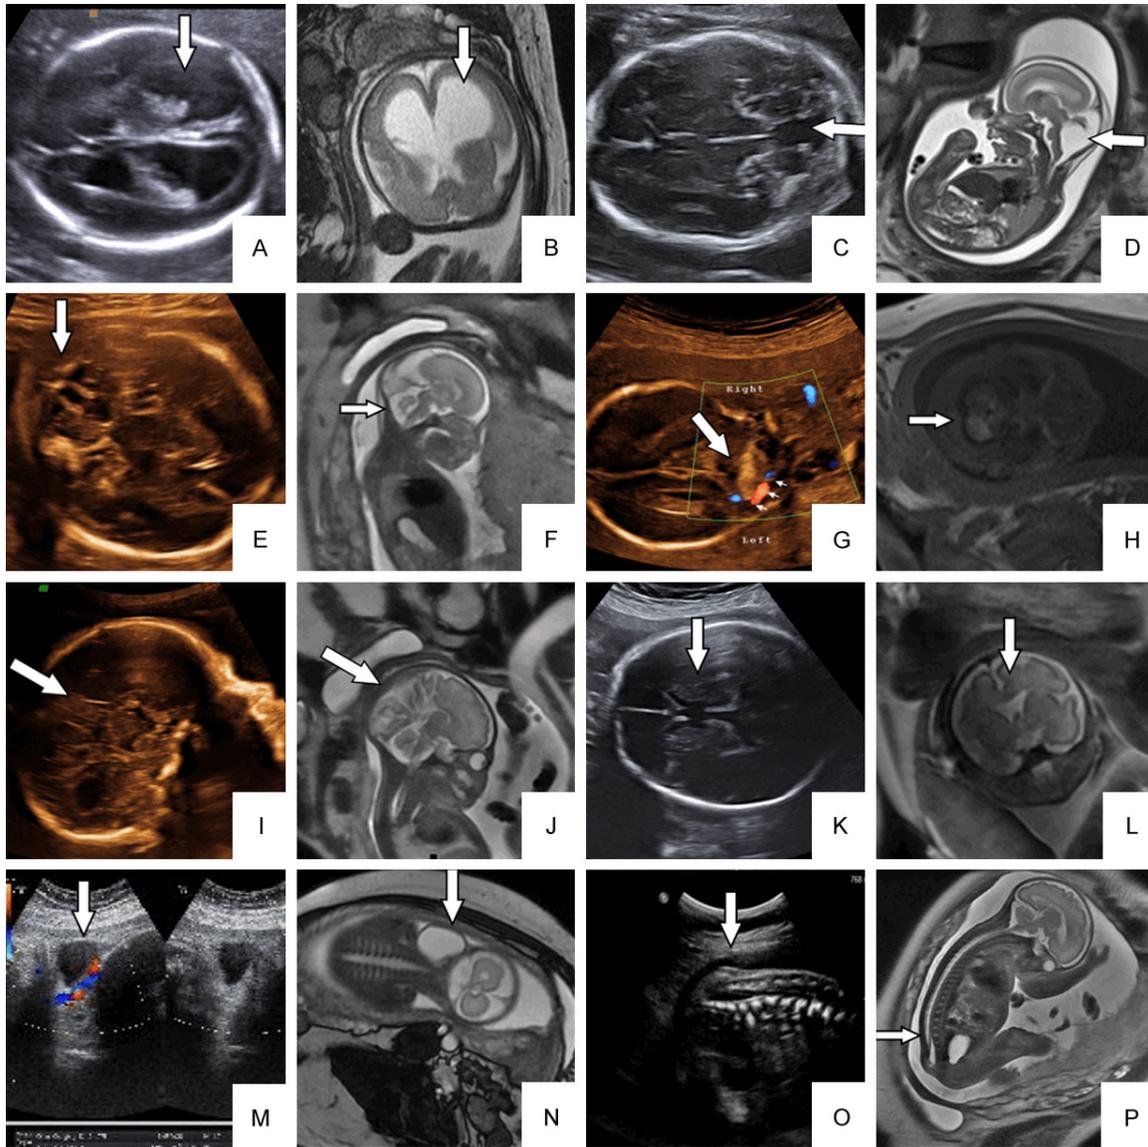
Examples of fetal cerebral abnormalities detected by ultrasonography and magnetic resonance imaging (MRI). (A, B) Hydrocephalus detected by ultrasonography (A) and MRI (B). The ultrasonography and T2WI showed significant supratentorial ventricular expansion and hydrocephalus, as well as thinning of the parenchyma of the cerebral hemispheres. (C, D) Dandy-Walker malformation detected by ultrasonography (C) and MRI (D). The bilateral cerebellar hemispheres and cerebellar vermis volume were small with partial absence and supination. The fourth ventricle was widened with cystic dilatation. Posterior fossa enlargement and uplift of the tentorium and transverse sinus were evident. (E, F) Blake's cysts detected by ultrasonography (E) and MRI (F). The development of the vermis was normal, but the fourth ventricle formed capsules that protruded into the posterior fossa. (G, H) Intracranial hemorrhage detected by ultrasonography (G) and MRI (H). There was left lateral ventricular enlargement, particularly in the inferoposterior aspect, combined with a local hematocele. (I, J) Absence of the corpus callosum detected by ultrasonography (I) and MRI (J). The sagittal image shows absence of the corpus callosum, cavum septum pellucidum and cingulate gyrus. The gyrus was arranged in a radial pattern. (K, L) Holoprosencephaly detected by ultrasonography (K) and MRI (L). The brain midline was broken at the cavum septum pellucidum, and there was interlinking of the anterior cornua. (M, N) Meningocele detected by ultrasonography (M) and MRI (N). (M) cystic mass filled with cerebrospinal fluid protruded from the left side of the neck. The spinal cord tissue protruding into the cyst was closely adhered to the cyst wall. (O, P) Tethered cord detected by ultrasonography (O) and MRI (P).
